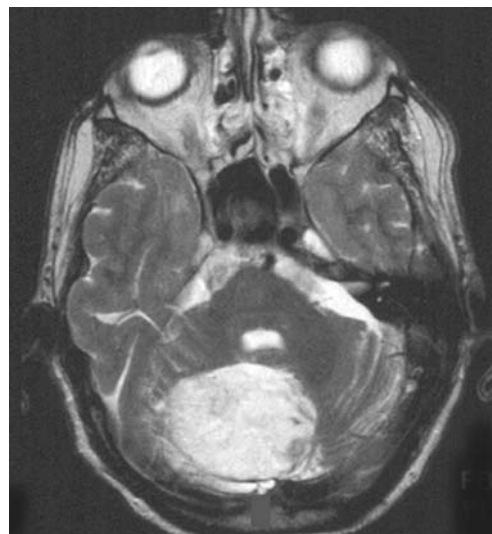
Axial MRI (T2-WI) with hyperintensity of infratentorial dermoid with severe mass effect and compression of the 4th ventricle (Patient 4)
